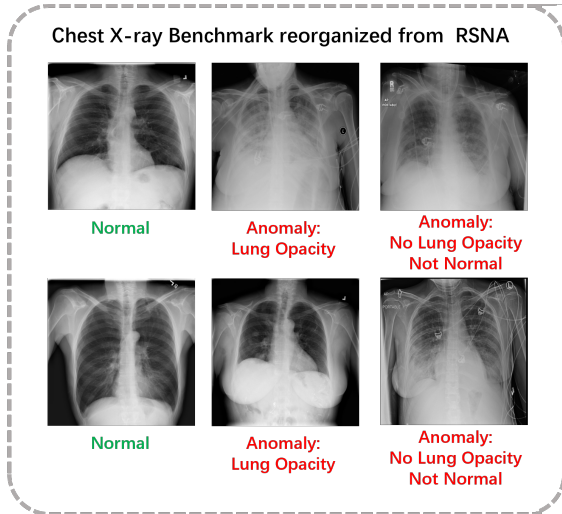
Our proposed chest X-ray benchmark consists two types of anomalies. These anomalies are clearly labeled in the images, and all of them are considered as anomaly samples.
